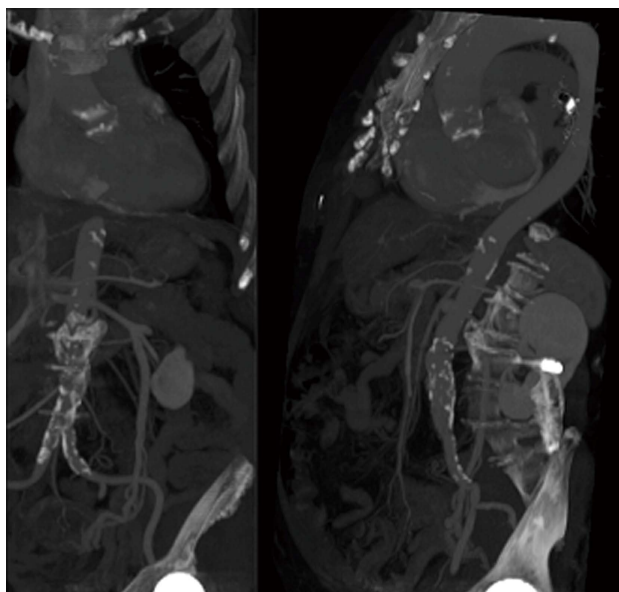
Computed tomography images showing aortic anatomy and calcifications, previous to transcatheter aortic valve implantation procedure.
